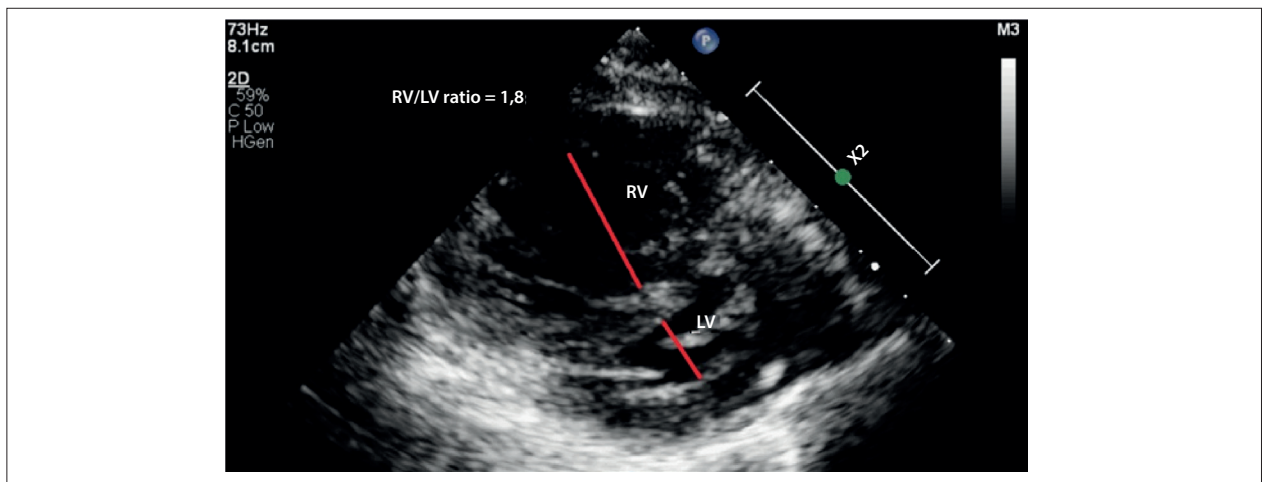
RV/LV ratio. The figure shows end-systolic parasternal short axis view of the ventricles. The arrows show measurements of left ventricular papillary muscles.
